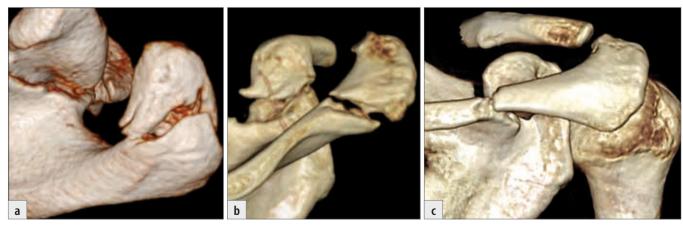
Acromial fractures — the classification developed by the authors, on 3D CT reconstructions: a) fractures of the anterior half of the acromion; b) fractures of the acromial angle; c) fractures of the lateral spine.
